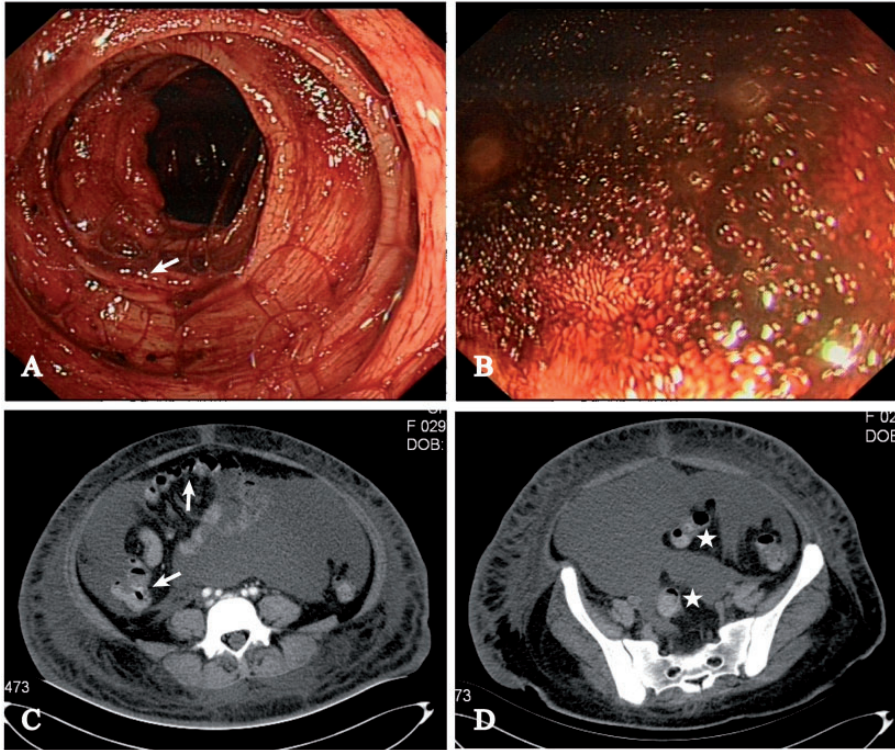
Endoscopy of the colon showing small intestine active bleeding combined with oedema (A) and hyperaemia(B). Enhanced computed tomography (CT) scans of the abdomen showing small intestinal wall was thickened (C, indicated by white stars) with associated marked enhancement (D, indicated by white arrows).
